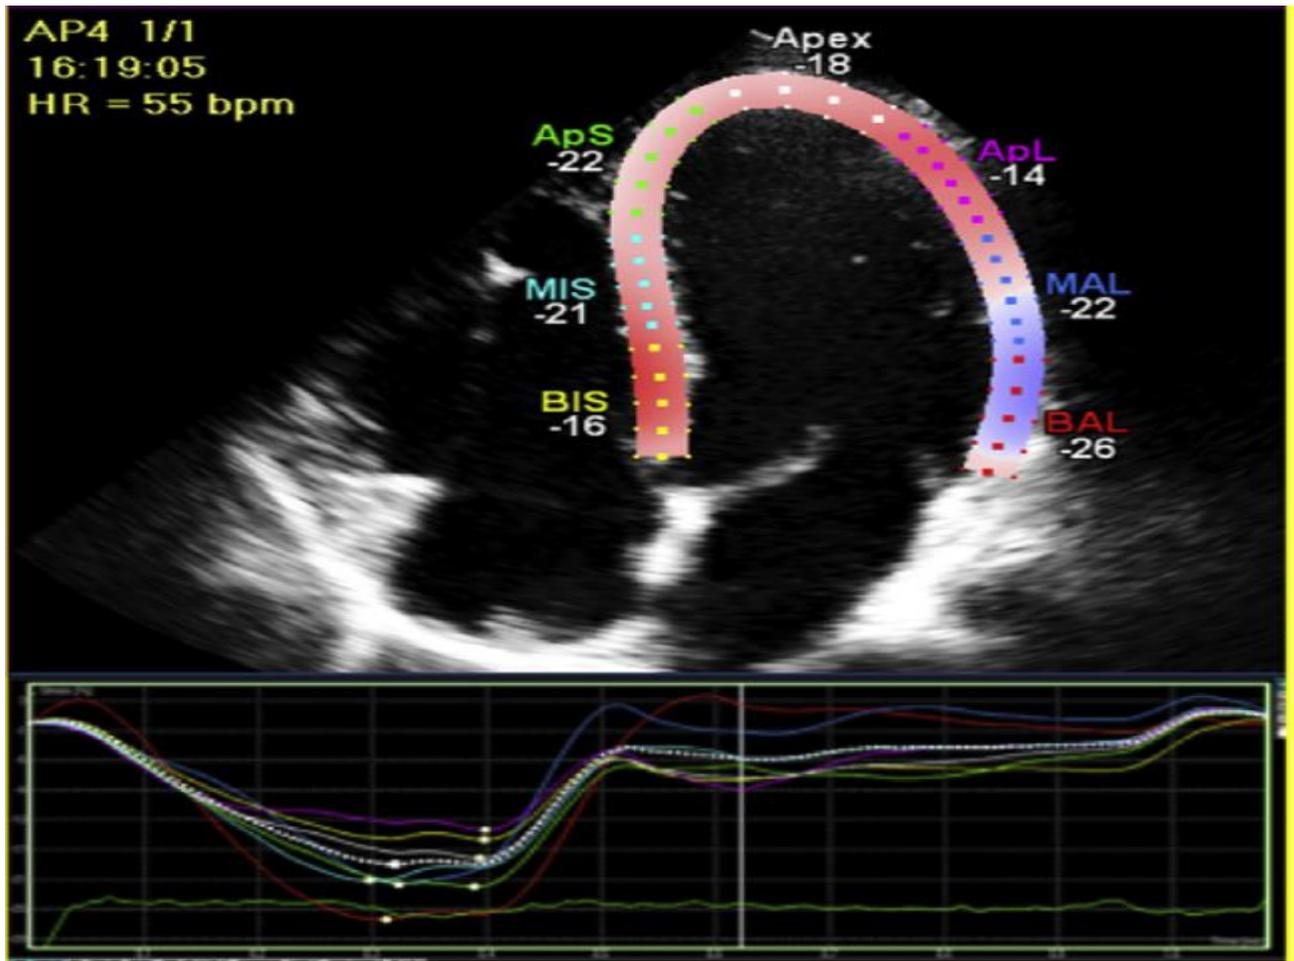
Peak values of global longitudinal ϵ were calculated using post-hoc speckle tracking of apical 4 chamber views. (Lang et al., 2015)
